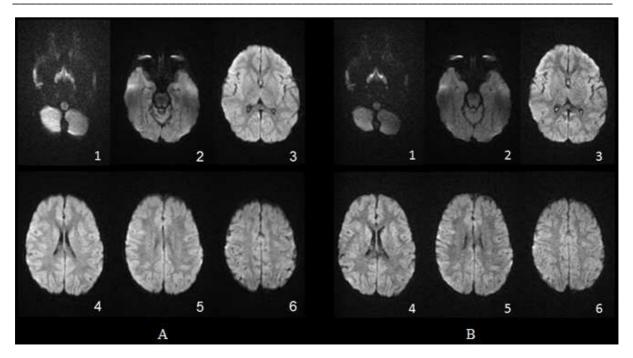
two series of the same slices of DWI series (A) acquired with conventional parameters and series (B) acquired in addition to dual spin echo
